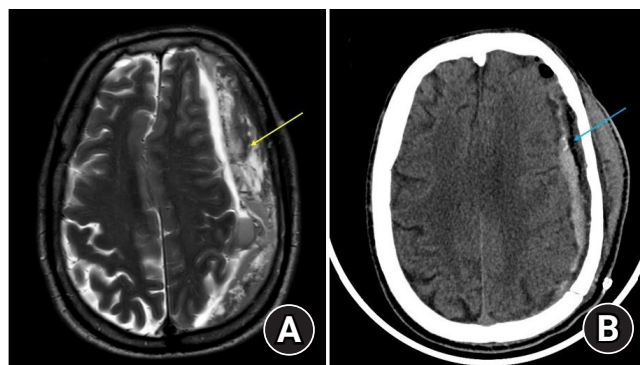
Shows the MRI (A) and CT scan (B) head of a 70/ male who underwent craniotomy for the trabecular (multiloculated) type of chronic subdural hematoma collection with significant mass effect.
